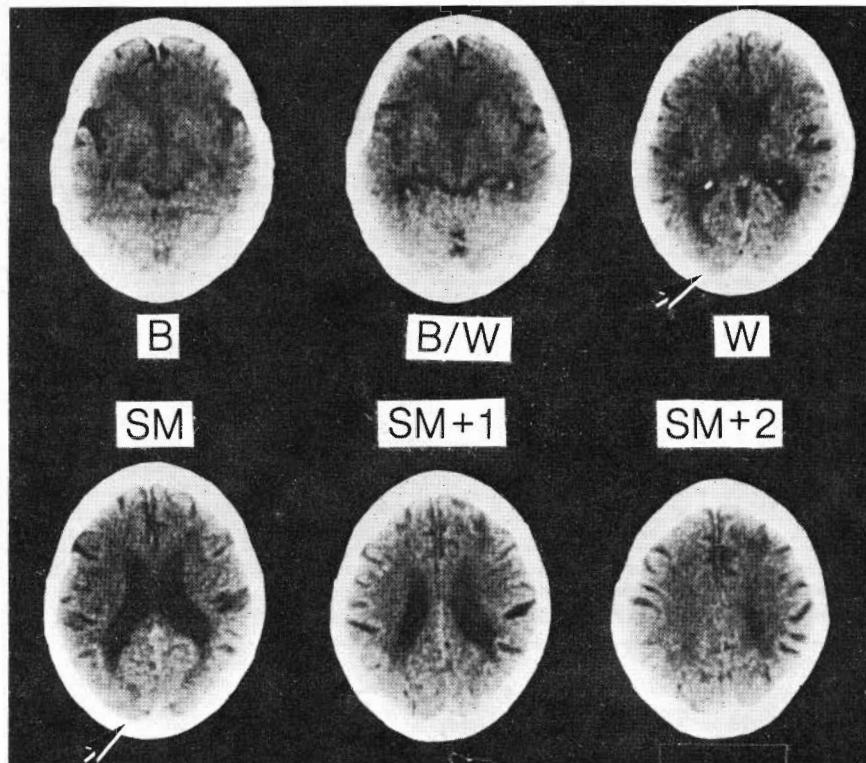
Patient 8 (see Table 1). Typical left computed tomographic scan occipital length asymmetry (arrows, slice W and slice SM). Occipital length asymmetry value at slice W was +10 (ratio, +0.037), and at slice SM was +10 (ratio, +0.037). Scan is dark because bone windows were used.
